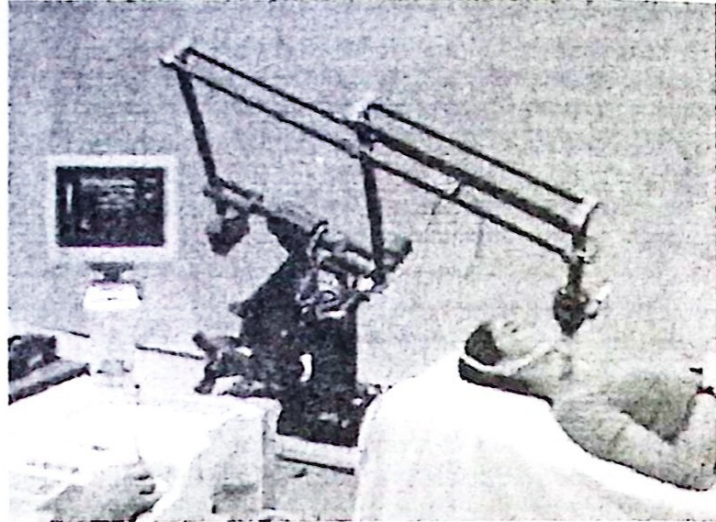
Ultrasound probe manipulation robot [70]
